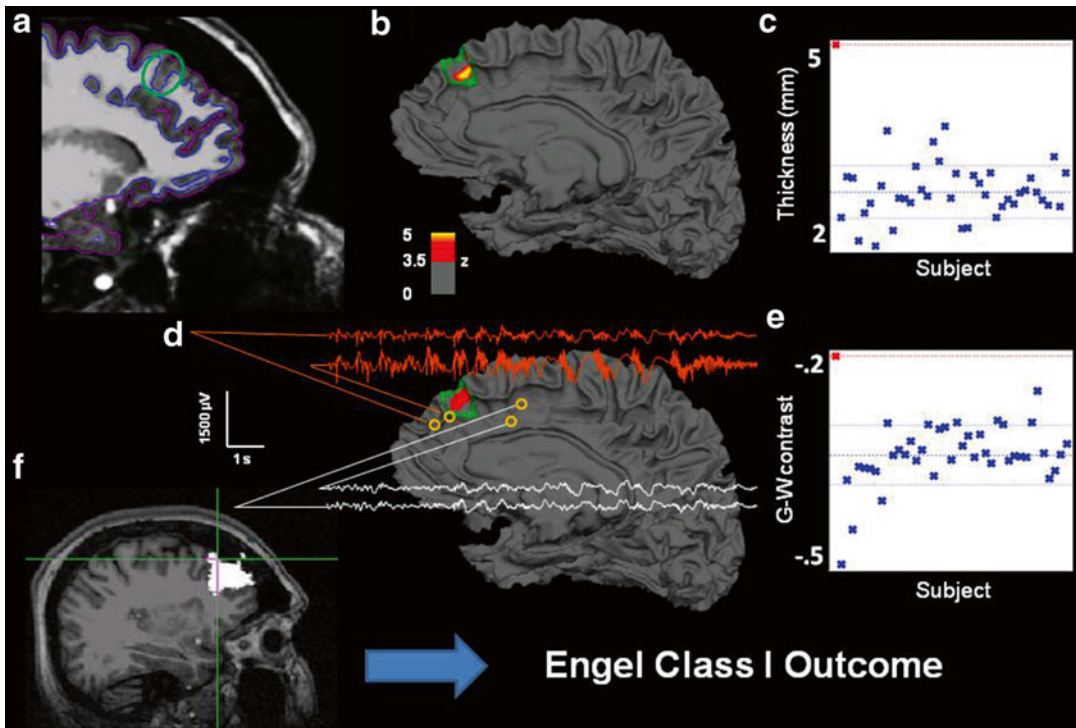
T1-weighted 3D anatomical MRI scan with imaging sequence optimized for gray-white matter contrast. Automated tracing of white matter (*green*) and pial (*blue*) surfaces
